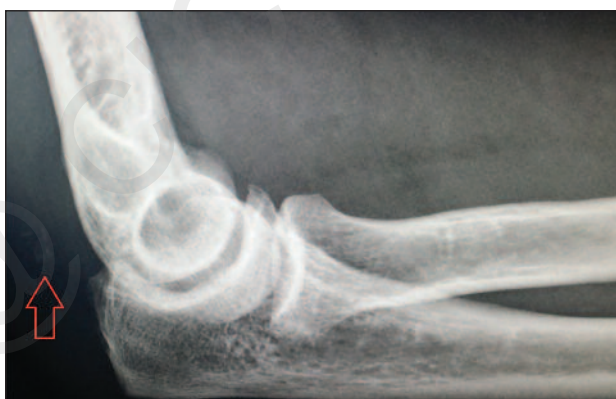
Radiograph of the elbow on admission shows a flake-like fragment proximal to the tip of the olecranon on lateral view (red arrow).
